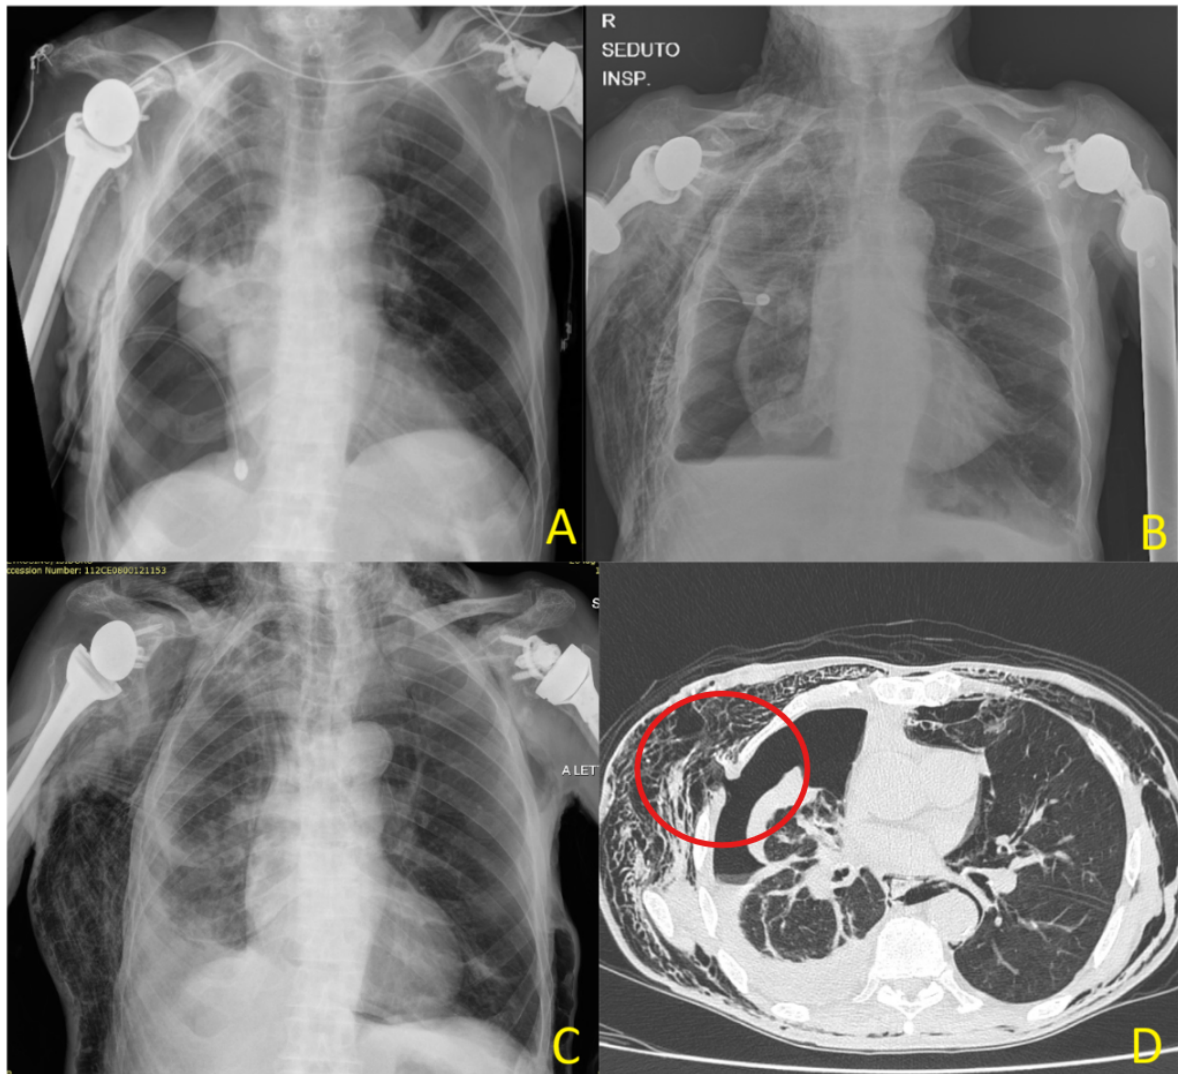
Radiological evolution of chest drainage-related complications. A) Chest X-ray (CXR) obtained after chest drain placement, showing a persistent air-fluid level consistent with non-expandable lung; B) CXR performed 36 hours later, demonstrating migration of the proximal drainage fenestrations into the subcutaneous tissue; C) CXR after chest drain removal, showing marked progression of subcutaneous emphysema; D) Chest Computed Tomography (CT) scan highlighting massive subcutaneous emphysema and a chest wall breach at the previous drain insertion site (red circle).
